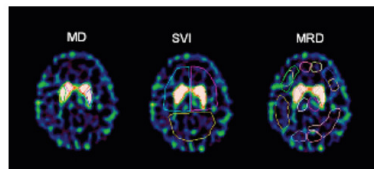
Three different methods of ROI delineation on SPECT images of same brain slice in same individual (Ziebell et al 2010b).
